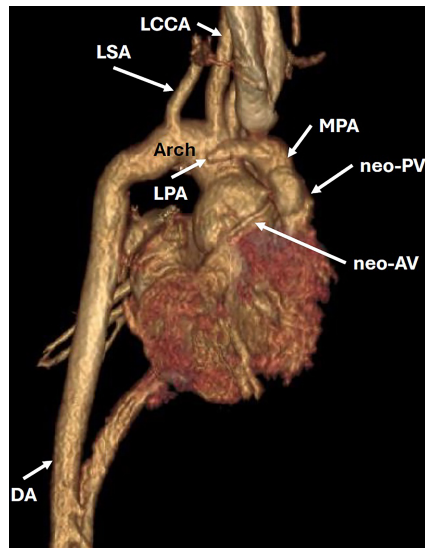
3D chest CTA with contrast in a sagittal projection. The left pulmonary artery is anterior to the aorta and is stenotic. The aortic arch is normal in size. There is neo-aortic valve dilation. DA, descending aorta; LCCA, left common carotid artery; LPA, left pulmonary artery; LSA, left subclavian artery; MPA, main pulmonary artery; neo-AV, neo-aortic valve; neo-PV, neo-pulmonary valve.
